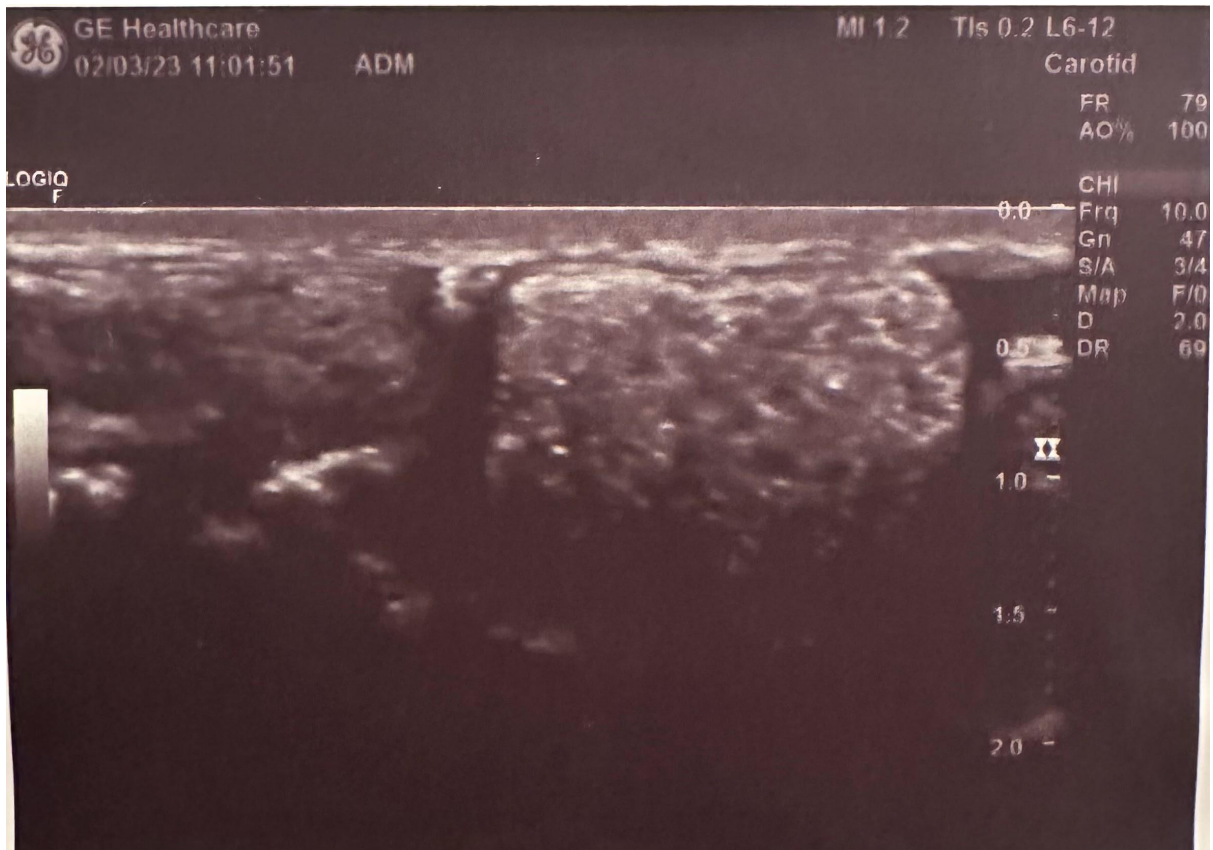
Transverse ultrasound scan of a hyperechoic intestinal loop with gas bubbles within the inguinal canal.
